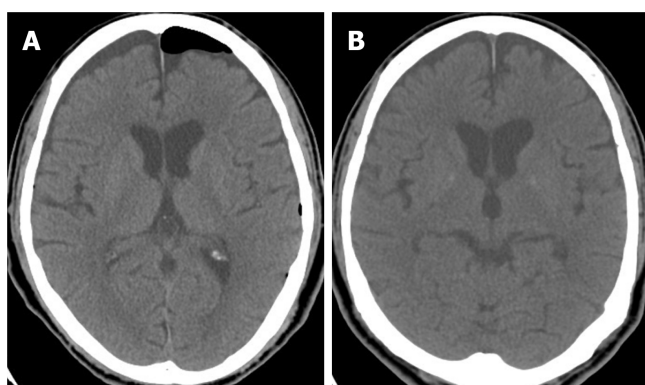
Post-operative computed tomography images demonstrate successful repair. A-B: Axial view of brain computed tomography on the 5th (A) and 15th postoperative day (B) showing resolution of pneumocephalus and pneumoventricle through subdural effusion accumulation without brain parenchymal compression.
